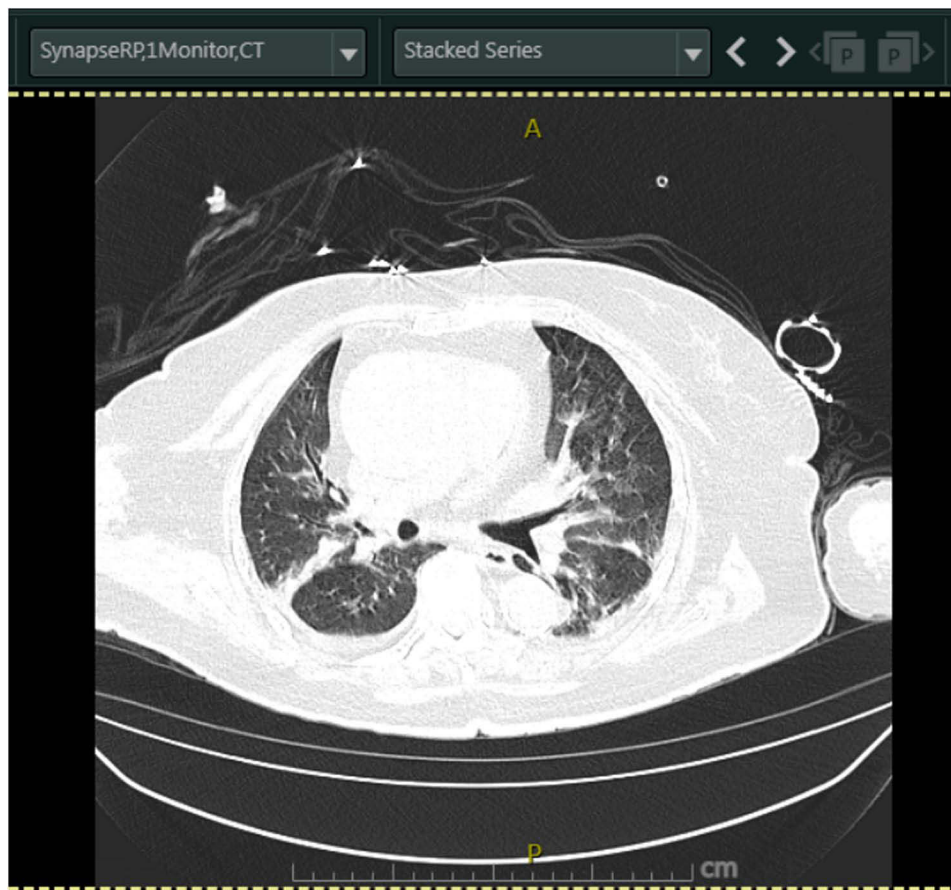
CT examination of bilateral interstitial lung lesions (Bilateral interstitial lung lesions, pulmonary edema, small bilateral pleural effusions, and bilateral pleural thickening).
